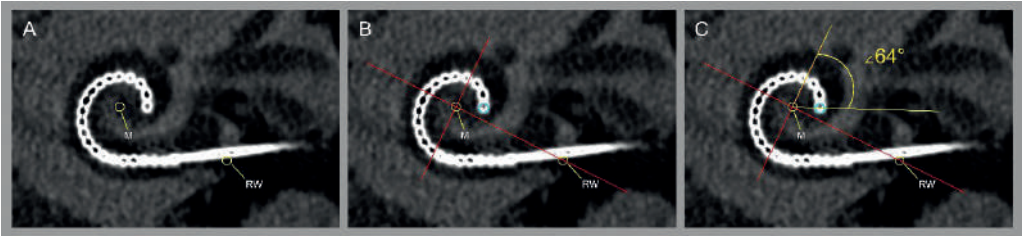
Method for the measurement of the angular insertion depth from a multiplanar reconstruction along the basal turn of the cochlea (A, B, and C) in an ultra-high-resolution computed tomography (UHR-CT) scan. A: An angular measurement of the insertion depth can be made by indicating the center of the round window (RW) and the modiolus (M). B: A 0° reference line was drawn between the modiolus (M) and the middle of the round window (RW), and a perpendicular line was drawn from the modiolus on the 0° reference line is drawn (red cross). The contact for which the angular insertion depth is to be measured is indicated (turquoise circle); in this case this is the most apical contact. C: An angle was drawn (in yellow) from the modiolus over the 270° reference line, and onto the most apical point of the electrode array (turquoise circle). In this example, the angular insertion depth of the most apical electrode contact is 334° (the sum of the three quadrants, equal to 270°, plus the measured yellow angle of 64°). The independent variables of interest were defined as the angle of insertion for the most basal (AOI1) and apical (AOI22) contacts.
